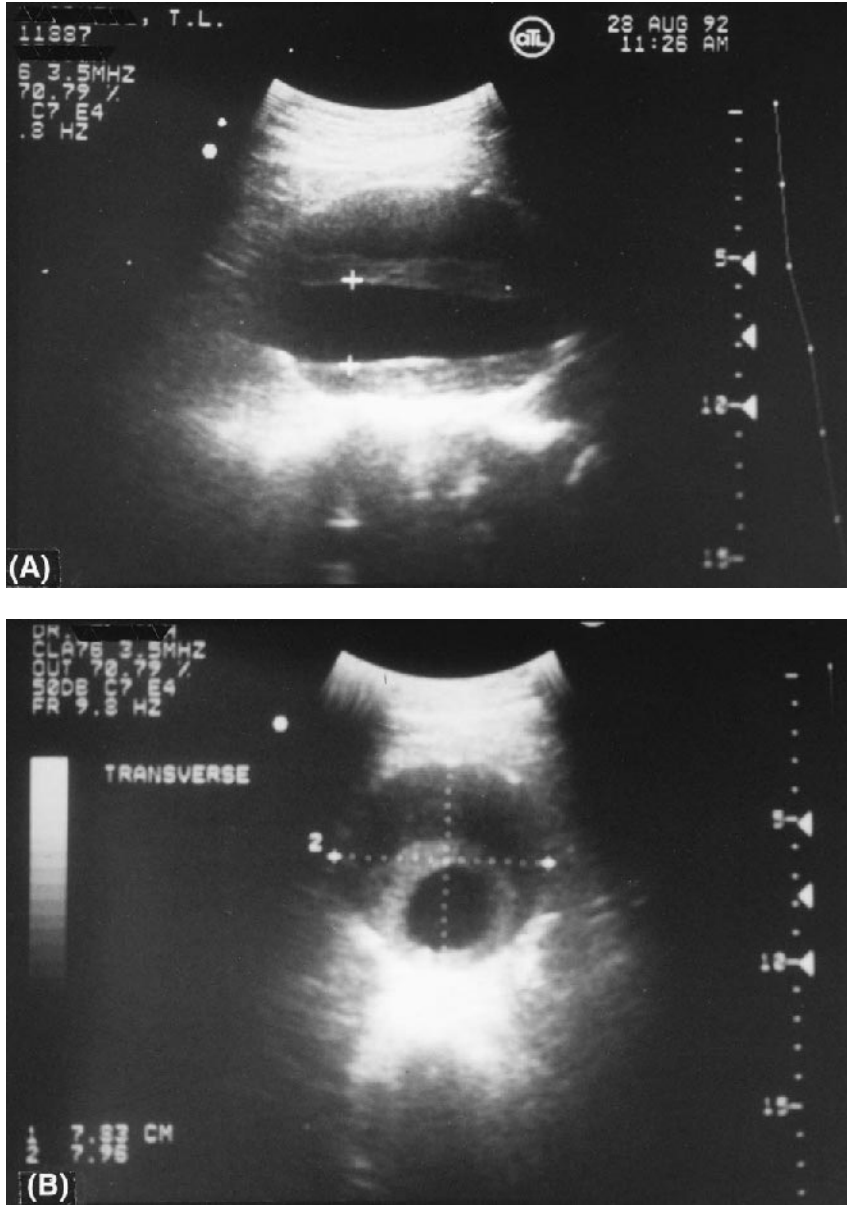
(A) Ultrasound with lateral view demonstrating a 6-cm infrarenal abdominal aortic aneurysm; (B) transverse ultrasound image of same aneurysm. Note large intramural thrombus within confines of the aneurysm.
